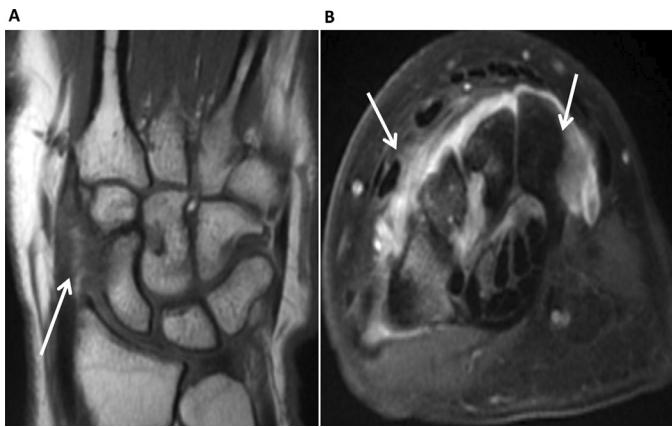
Magnetic Resonance Imaging of the left wrist. (1A) T1W coronal sequence showed synovial hypertrophy and thickening (white arrow). (1B) Axial T1W fat suppressed postcontrast image at the level of carpal bones, demonstrated enhancing synovial hypertrophy along the dorsal aspect of the wrist (white arrows).
